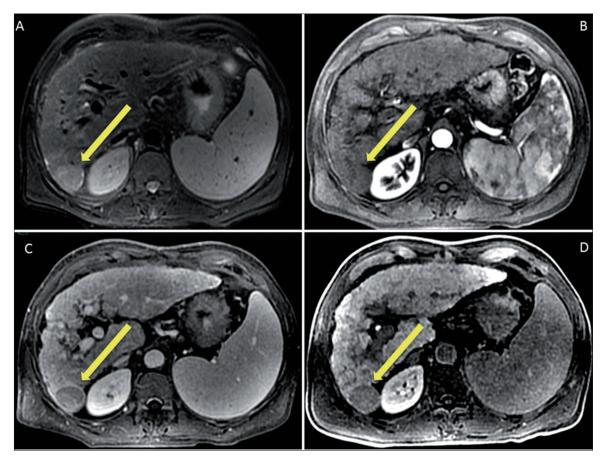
Hypovascular HCC. A, On T2-weighted fat suppressed axial image an hyperintense lesion is shown in the VI segment. B, At dynamic imaging, in the arterial phase, the lesion is hypovascular. C, The nodule appears hypointense in the venous phase. D, In delayed phase imaging the nodule is definitely hypointense relative to surrounding liver parenchyma.
